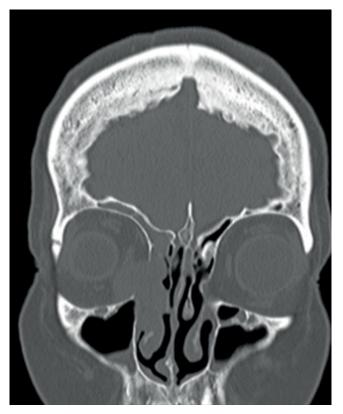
Coronal CT of a right nasolacrimal sac transitional cell papilloma demonstrating bony erosion and orbital infiltration.
